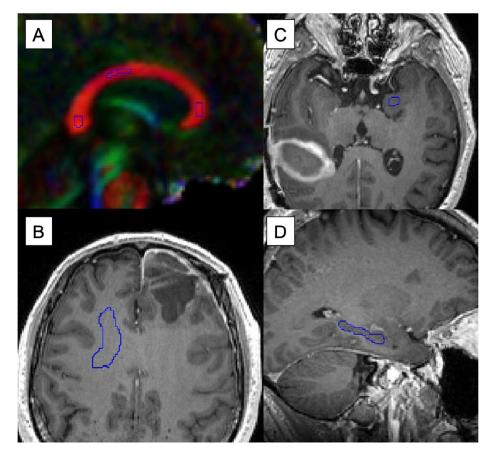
Placement of Regions of interest (ROI) A. The corpus callosum on a FA-color map. The ROI placed within the structures from left: splenium, corpus and genu, viewed at a sagittal view. B. The centrum semiovale in the right hemisphere on a post contrast T1-weighted image, viewed on the transversal plane. C. The amygdala in the left hemisphere on a post contrast T1-weighted image, viewed on the transversal plane. D. The left hippocampus on a post contrast T1-weighted image, viewed on the transversal plane. D. The left hippocampus on a post contrast T1-weighted image, viewed on the transversal plane.
